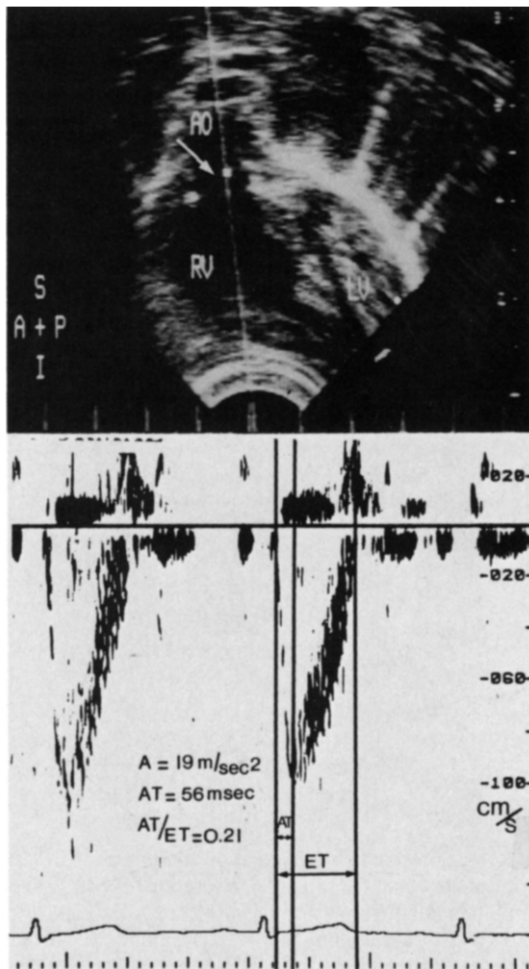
Pulsed Doppler echocardiographic assessment of right ventricular performance. Top, Subcostal imaging in a patient with aortopulmonary transposition after intraatrial repair, demonstrating the ascending aorta (AO) located anteriorly (A) and arising from the right ventricle (RV). The Doppler sample volume (arrow) is placed just above the aortic valve. Bottom, Pulsed Doppler tracing of the aortic blood flow recorded in a normal subject. The way acceleration time (AT) and ejection time (ET) were measured is demonstrated, and the values for AT, AT/ET and mean aortic acceleration ($A = \text{peak velocity}/AT$) are given. Peak and mean aortic flow velocity values in this subject were 96 and 61.4 cm/s, respectively. I = inferior; LV = left ventricle; P = posterior; S = superior.
